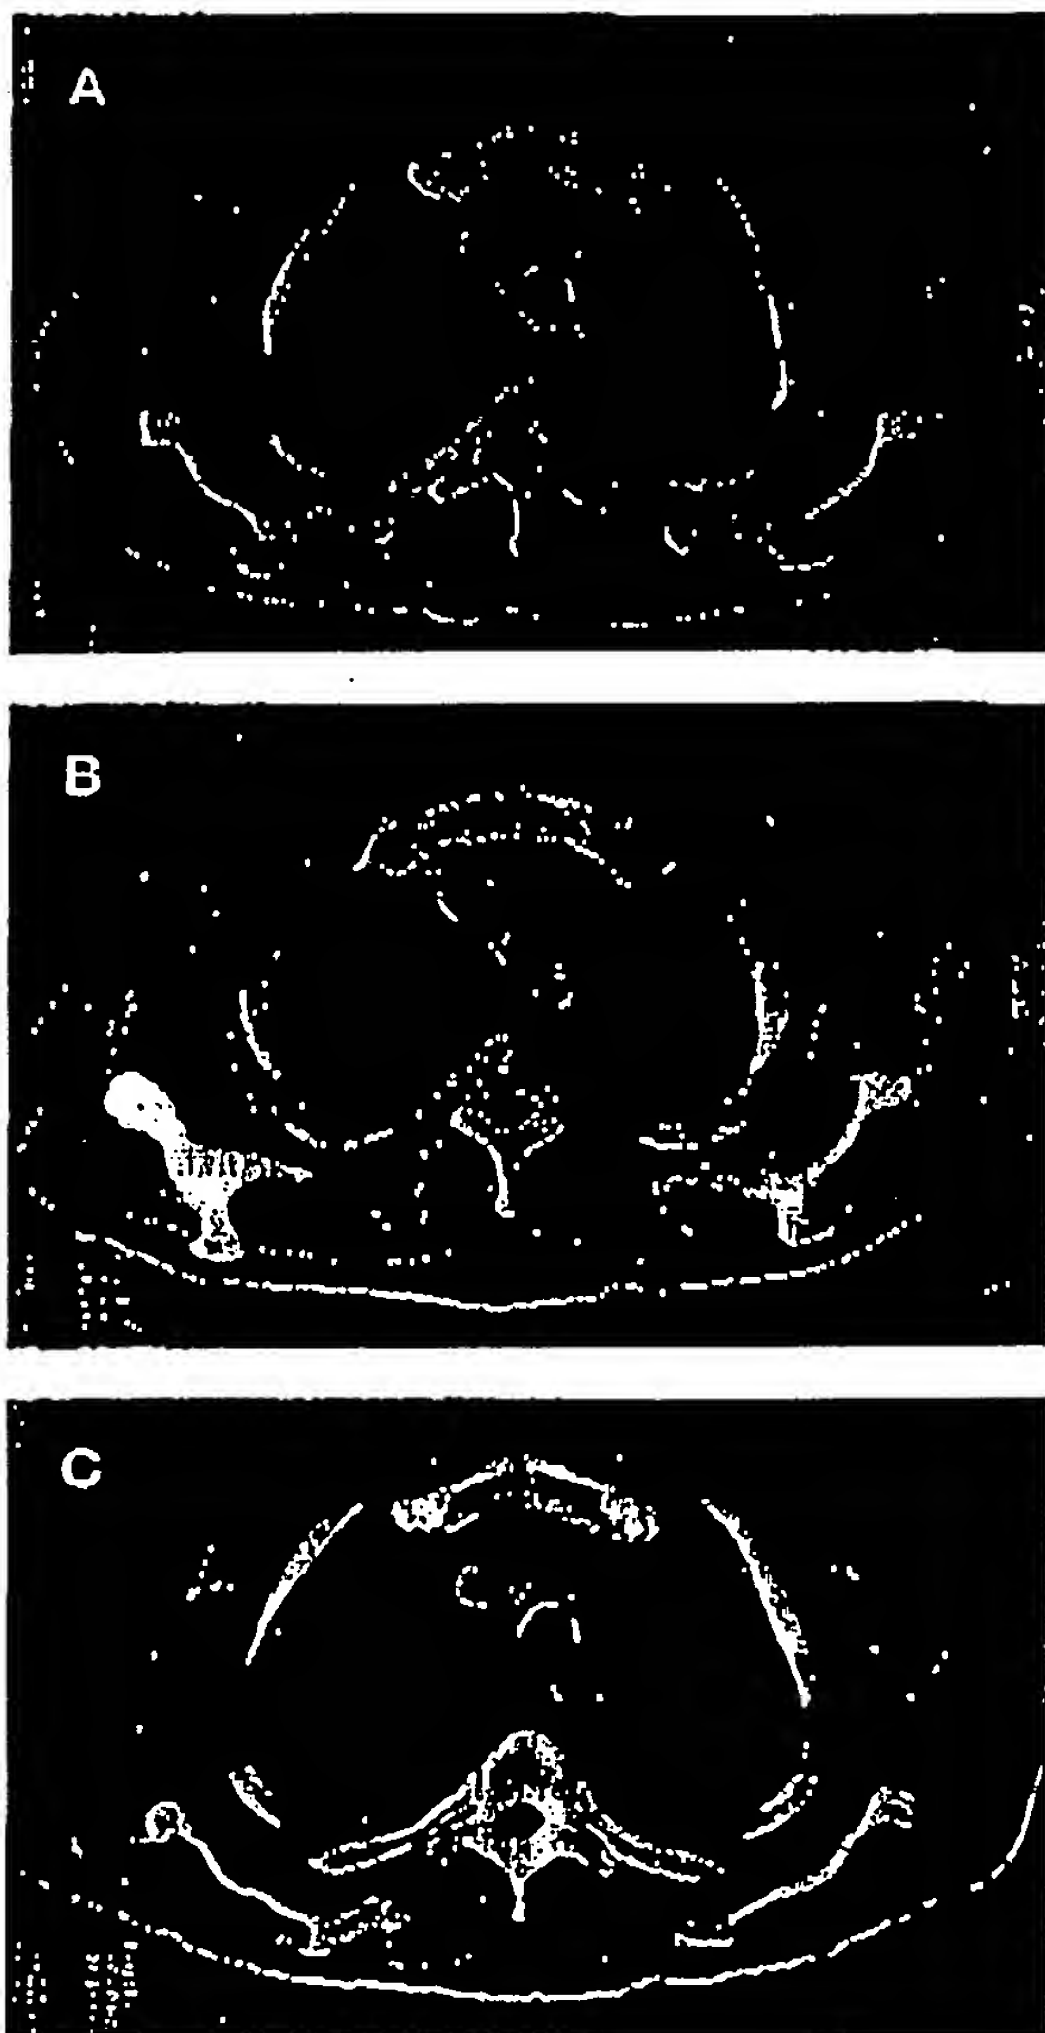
CT scans from baseline (A), 6 weeks (B), and 3 years (C) after treatment for patient no. 8 show a complete response of his bilateral axillary nodal disease.
